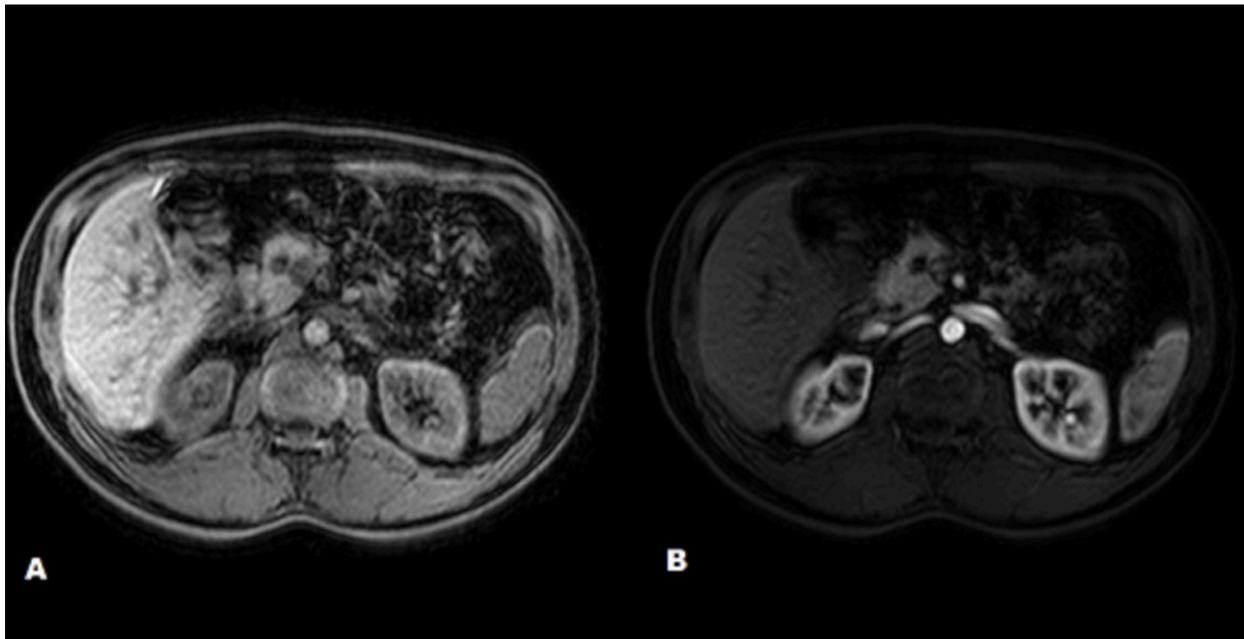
MRI axial dynamic sequences showed pancreas with normal dimensions, but with expansive lobulated formation in its tail, with a solid component and cystic degeneration. References: Radiology Department, São Carlos Imagem, São Carlos Hospital - Fortaleza/BR 2018
